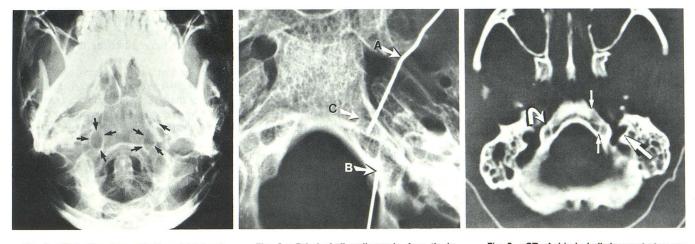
Plain film demonstration of bilateral pseudoforamina, more prominent on right (*arrows*).
